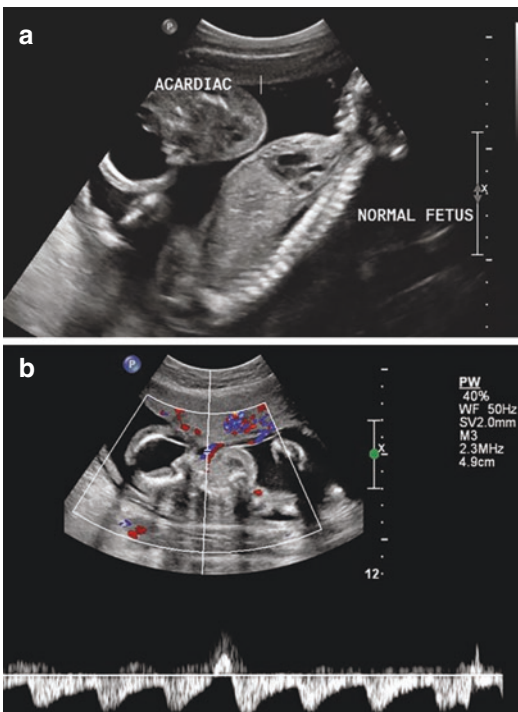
TRAP sequence. (a) The acardiac twin is in the upper part of the image, as marked. Some vague anatomy can be recognized. (b) Doppler velocimetry demonstrates flow away from the transducer in the umbilical artery of the acardiac twin, i.e., reversed, from the placenta toward the fetal body
